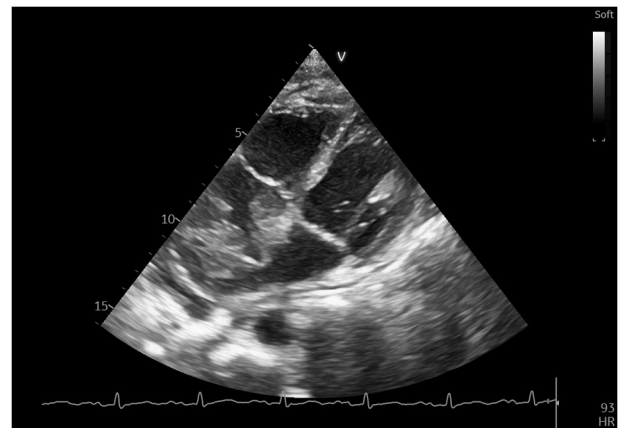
Echocardiography at 3 weeks after the initial evaluation (modified apical four chamber view) revealing growth of the tumoral mass, infiltrating the right atrial area, the left atrium and interatrial septum and extending to the base of the left and right ventricles. HR, heart rate.
